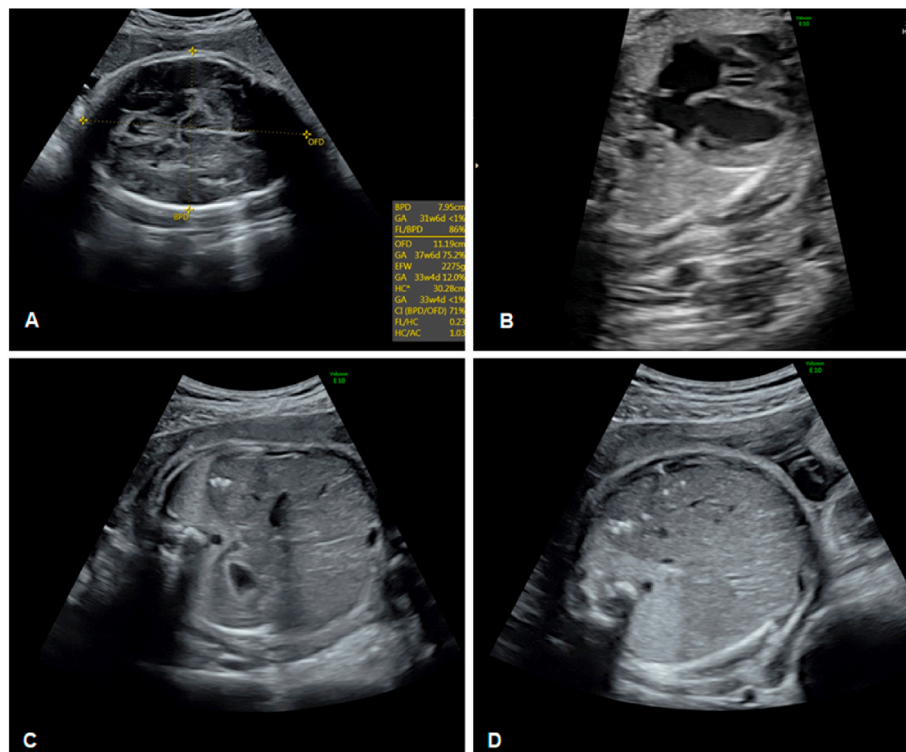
Prenatal ultrasound performed at 31 weeks of gestation showed an abnormal cranial shape with dolichocephaly (A), abnormal cardiac axis (B) and liver calcifications (C–D).
